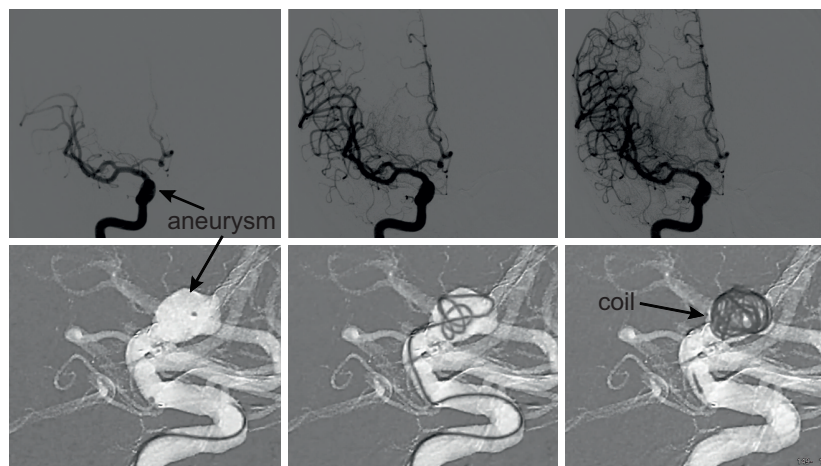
X-ray scan of the propagation of a bolus of CA from the tip of a micro catheter into a human brain (top). DSAs of a catheter-based intervention during the coiling of an aneurysm (bottom). The vascular system appears bright on the road map because it is a subtraction image. The image acquisition was performed by Dr. C. Riedel, Clinic for Neuroradiology, Universitätsklinikum Schleswig-Holstein, and reproduced with his permission.
